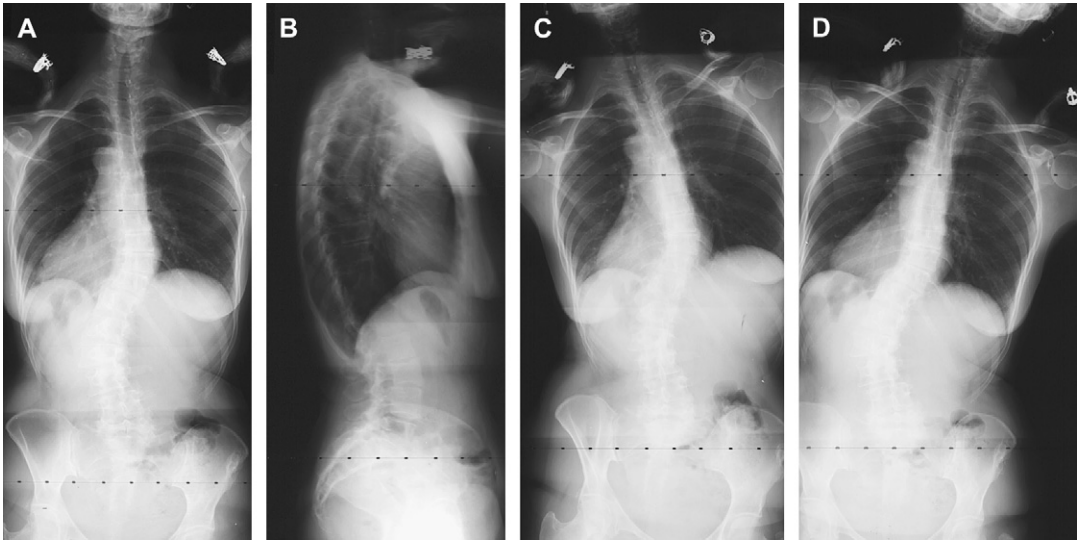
Standard AP (A), lateral (B), and left- (C) and right- (D) side-bending radiographs of a 62-year-old woman with degenerative lumbar scoliosis and spinal stenosis.
